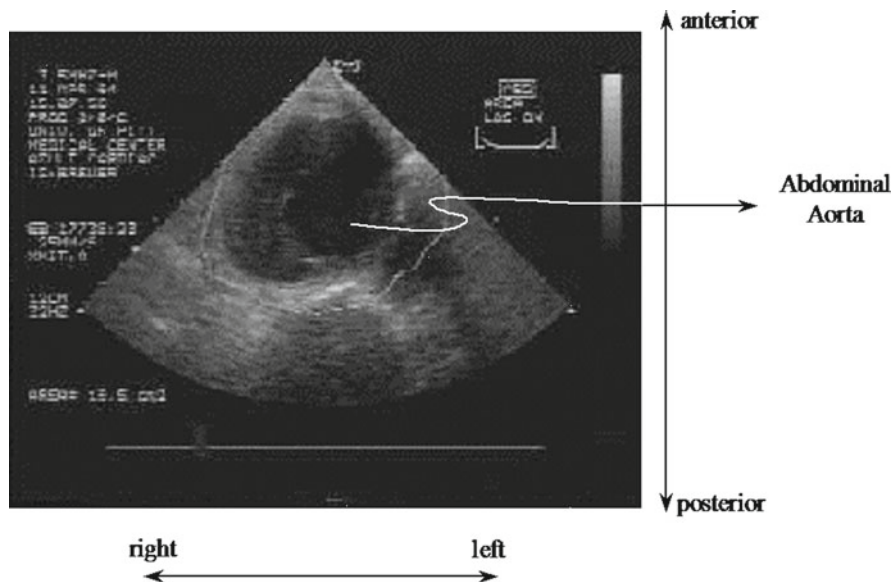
Transabdominal ultrasound of human AAA. The imaging modality may be well suited for diagnosing the presence (or the absence) of an AAA, but perhaps of insufficient resolution for extracting its 3D geometry accurately
